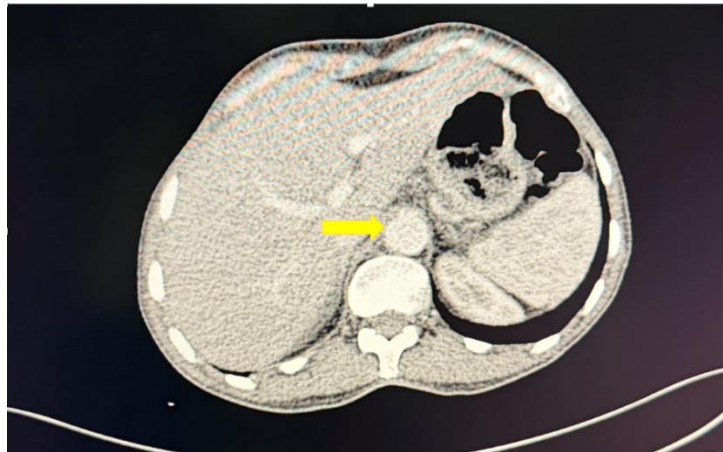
Contrast-Enhanced CT Angiography Demonstrating Distal Aortic Thrombosis (arrow)
